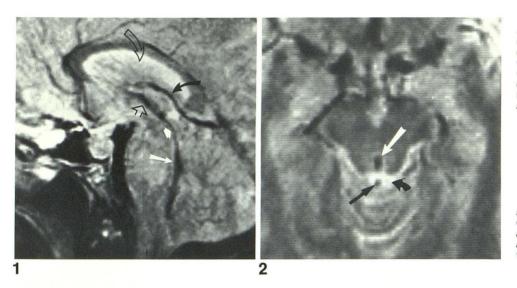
T2-weighted midsagittal image, SE 2500/80. CSF flow-void sign (loss of signal) in posterior third ventricle (straight open arrow), aqueduct (short white arrow), and fourth ventricle (long white arrow). CSF in lateral ventricle (curved open arrow) is bright. Flowing blood in internal cerebral vein (curved solid arrow) is dark.
